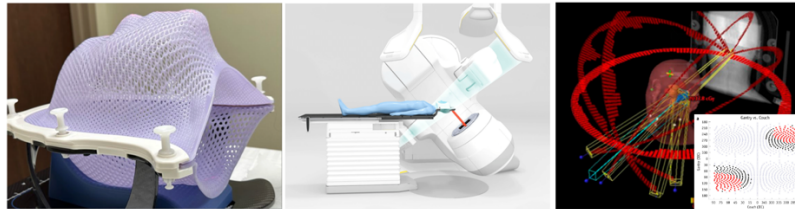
left, thermoformed masks used for immobilization in head radiotherapy; middle, treatment using surface tracking with camera and x-ray imaging; and right, beam trajectory optimization.
